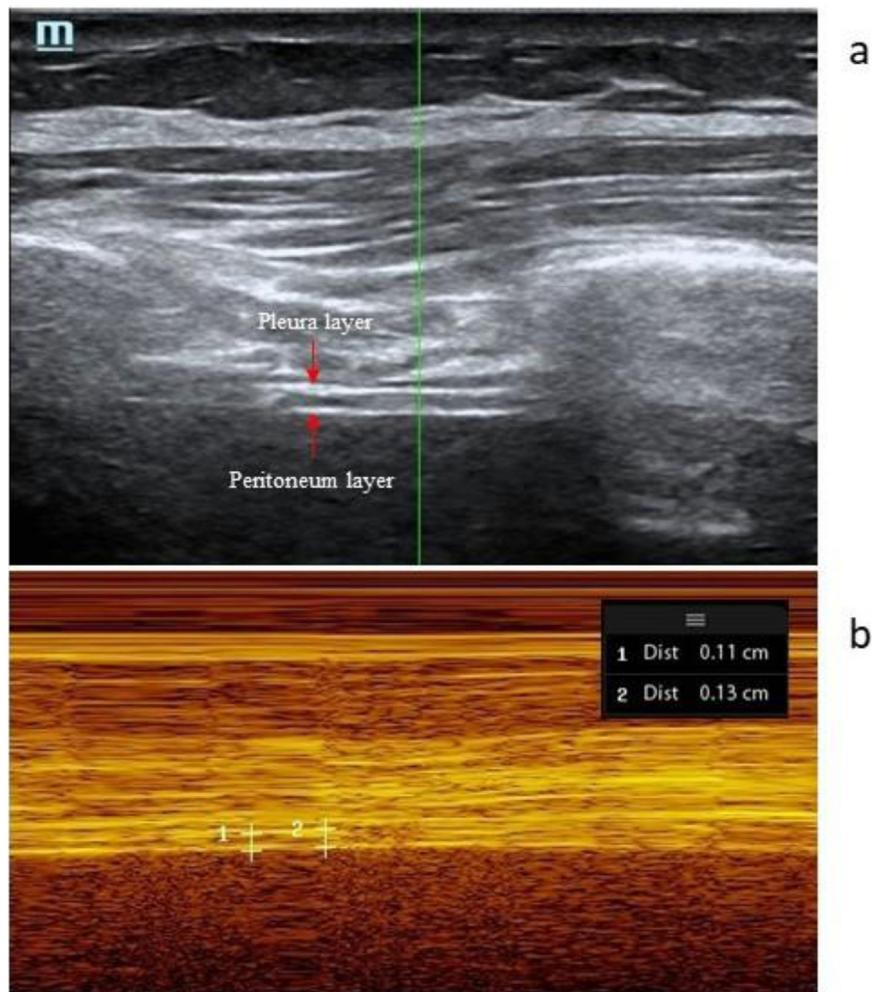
Ultrasound images. Right diaphragm exploration. (a) 2D mode. (b) M-mode ultrasound of the diaphragm. Measurement of diaphragm thickness using M-mode at the level of the right hemidiaphragm. Is visualized as 3 parallel lines. Number 1 represents the inspiratory thickness and number 2, the expiratory thickness.
